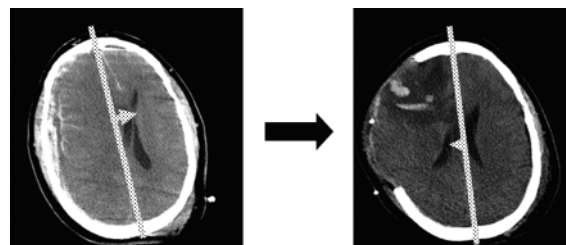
Computed tomography scans showing postoperative reversal of midline shift. A preoperative CT scan (*left*) demonstrates a right acute SDH with right-to-left midline shift (*arrow*). A postoperative CT scan (*right*) obtained after DC shows extracranial herniation and midline shift from left to right (*arrow*).
